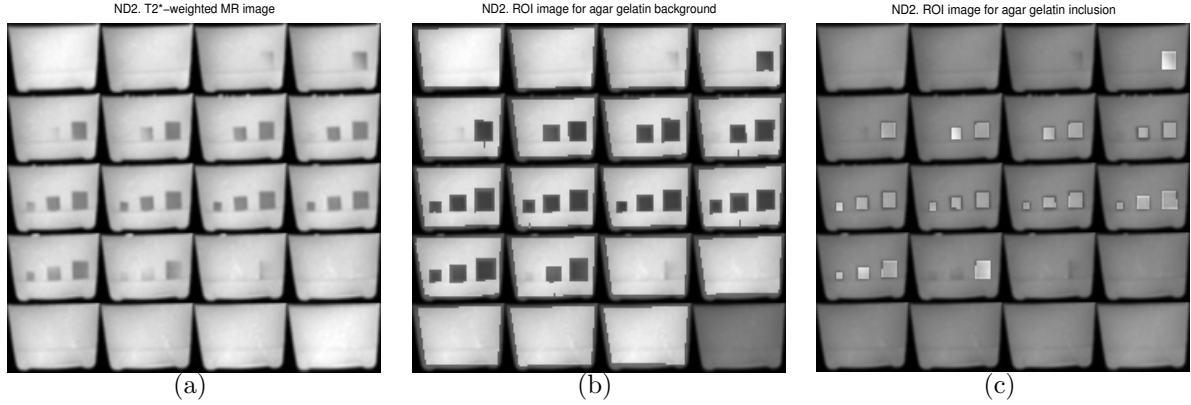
MRI image results of the ND2 with ROI selections indicated: (a) High resolution T2* weighted MR image; (b) MR image (background ROI indicated); (c) MR image (inclusion ROI indicated).
